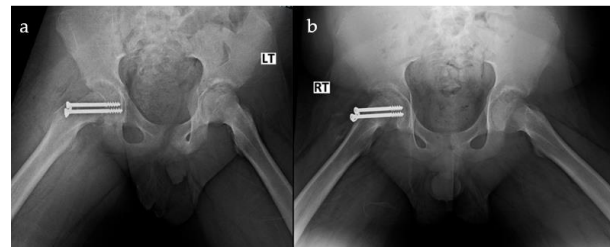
Immediate postoperative radiographs following in situ fixation of right-sided SCFE in an 11-year-old boy using two cancellous screws. An open-insertion technique was used to carefully determine the entry points and avoid injury to the retinacular vessels.
